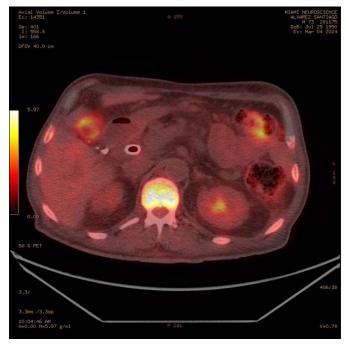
Most recent PET/CT 03/2024 showing little FDG activity at the pancreatic head and resolution of ascites.
